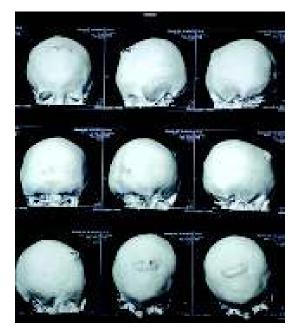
Pre-op, 3D CT scan
